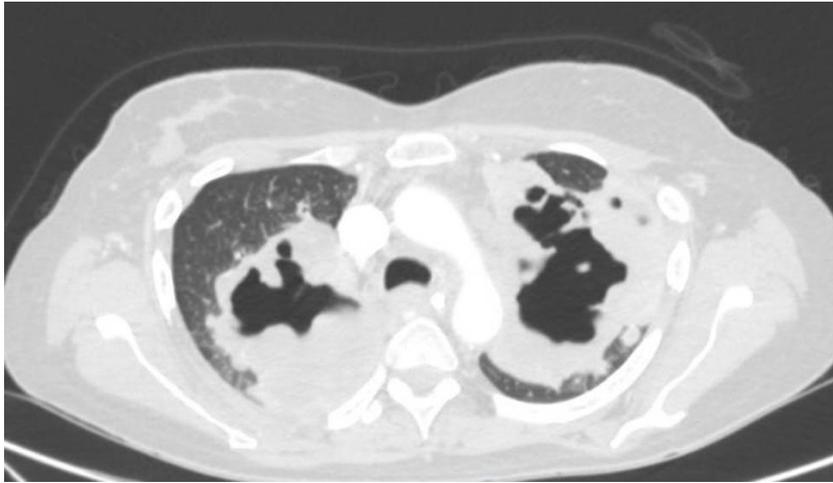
Axial view of Chest CT showing two lobulated large perihilar cavitory lesions with thick walls involving bilateral apices with internal cystic components.
